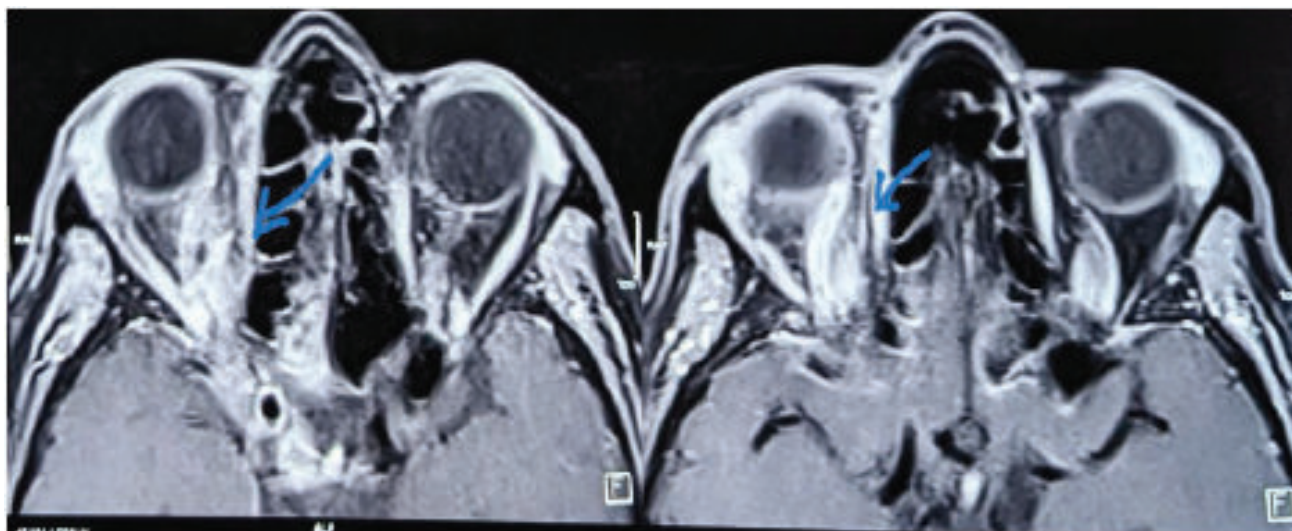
Axial MRI image with contrast showing right retro-bulbar soft tissue abnormalities.
